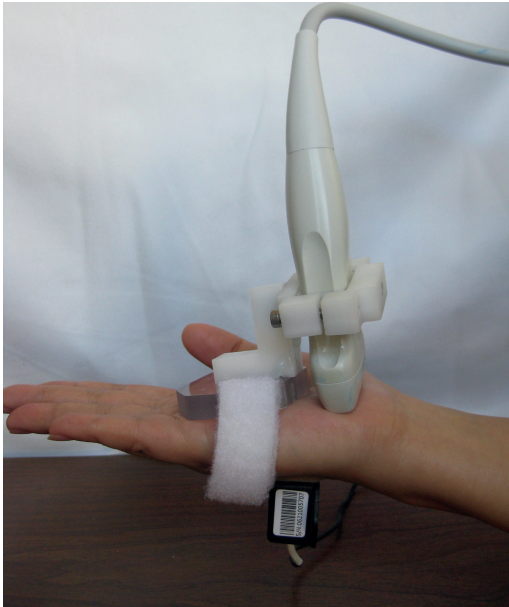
Ultrasound examination setup. The transducer was placed at the proximal carpal tunnel. A custom-made transducer-fixing device was fastened at the subjects' palm to keep the transducer stable during finger or wrist motion. A goniometer was fixed on the back of hand to measure the wrist angle during wrist movement.
